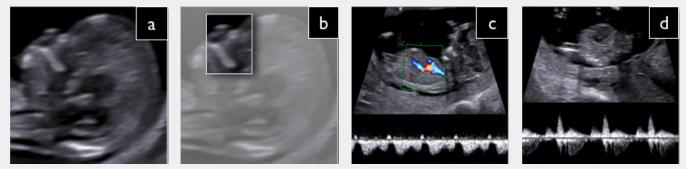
c and d. Evaluation of an uploidies by ultrasound markers such as nuchal translucency (NT), nasal bone (NB), Ductus venosus (DV), and tricuspid flow (TF)
